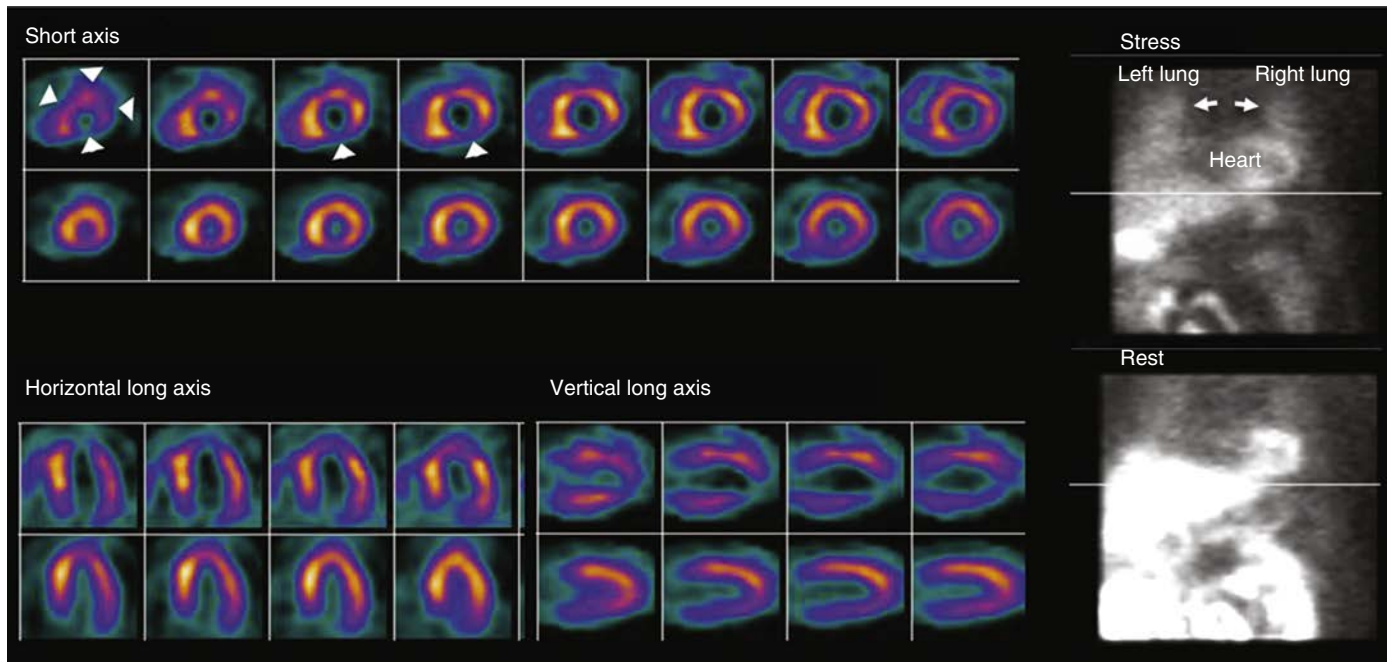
Exercise stress and rest myocardial perfusion single positron emission computed tomography (SPECT) images in a patient with atypical angina. The study shows transient cavity dilation during stress (so-called transient ischemic dilation [TID]), transient increased tracer uptake in the right ventricular free wall, extensive multiterritory defects (*arrowheads*), and increased pulmonary retention of the radiotracer after stress (*arrows*). Taken together, these findings are consistent with multivessel coronary artery disease (CAD) and are associated with clinical risk for adverse events.
